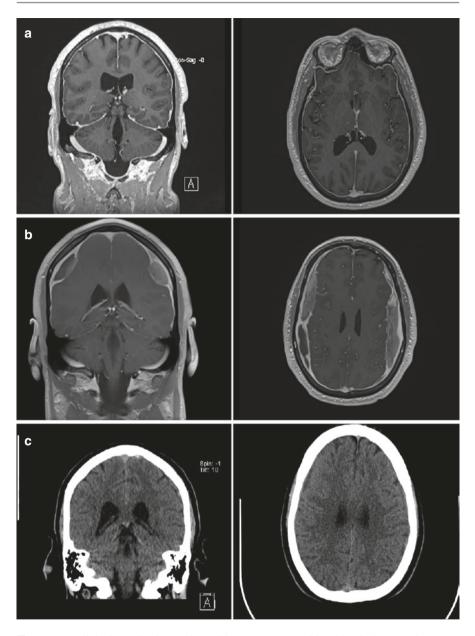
Radiologic studies in a patient with spontaneous positional headache secondary to an occult cerebrospinal fluid leak. (a). Initial contrast enhanced magnetic resonance imaging (MRI) is consistent with intracranial hypotension with pachymeningeal enhancement constrained to the dural surfaces and sparing the deep cortical sulci. Symptoms were relieved following spinal epidural blood patch ×2. (b). Progressive intermittent headache and hemisensory symptoms developed at 12 weeks. MRI now shows bilateral mixed subdural hematomas treated successfully with burr hole evacuation (c)
